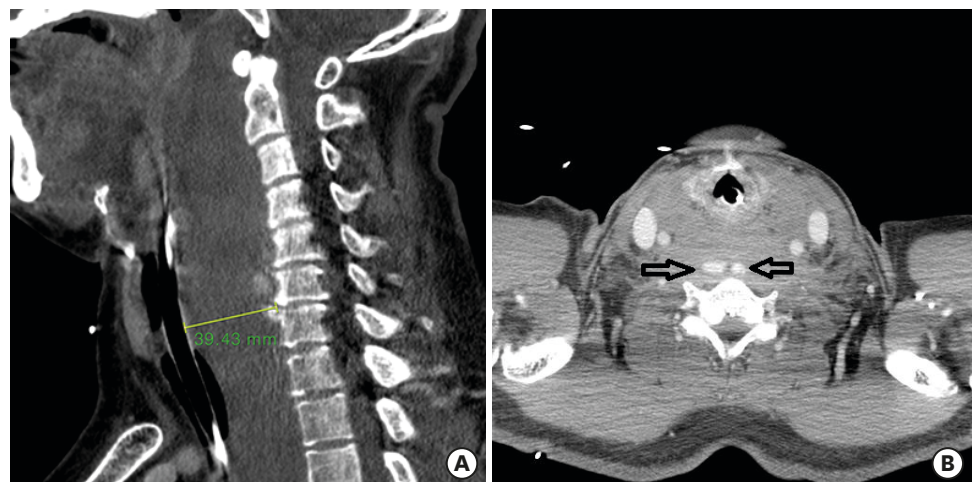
Subsequent enhanced CT scan when the patient returned to ED. (A) Massive retropharyngeal hematoma extending from base of the skull to posterior mediastinum. (B) Active contrast leakage (arrow) at the C6–7 level.
